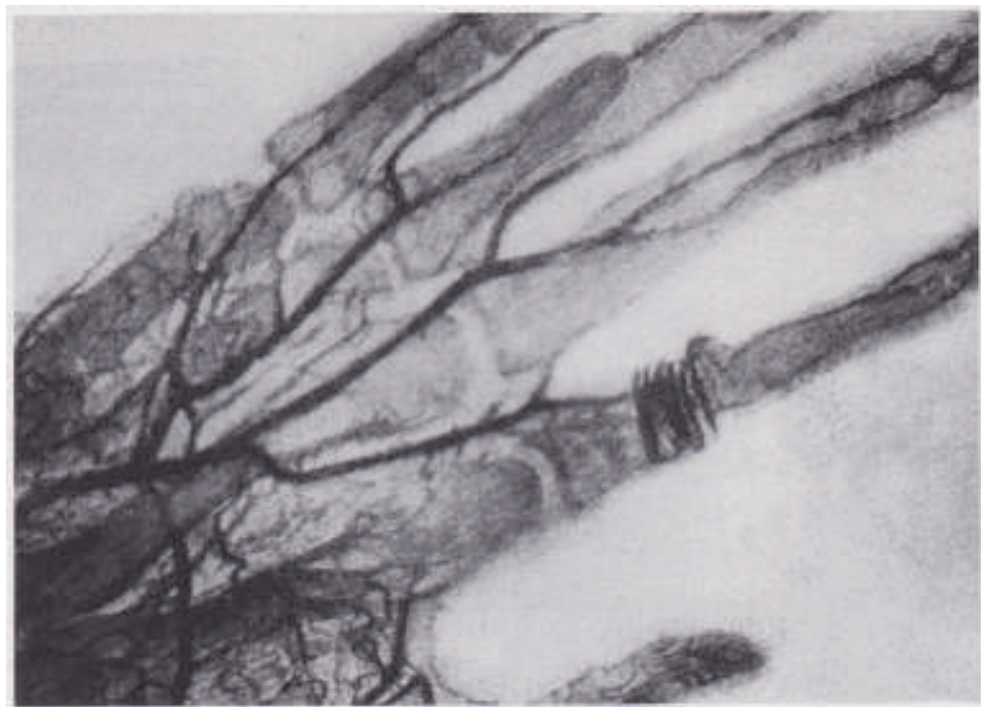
A roentgenogram made by Haschek and Lindenthal after the injection of Teichman's mixture into the blood vessels of an amputated hand (Haschek E. Lindenthal O'F. A contribution to the practical use of the photography according to Röntgen. *Wien Klin Wochenschr* 1896:9:63.).
